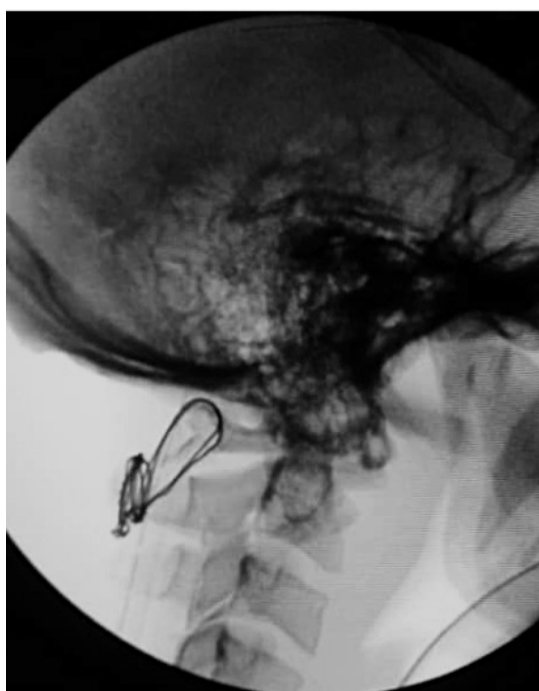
Case 2 Postoperative control X-ray (On C arm fluoroscopy).
